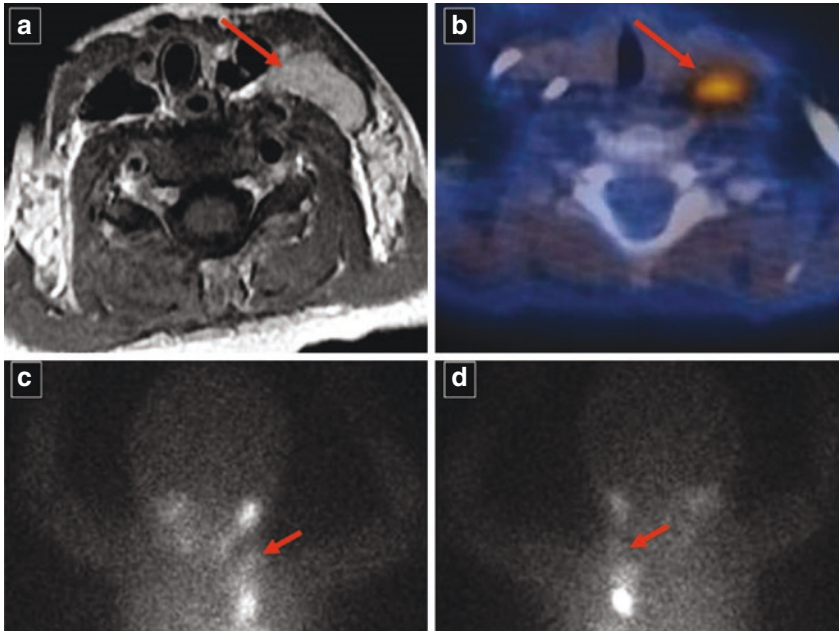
Example of a patient with primary NB diagnosis showing an ancillary nodal involvement in the left supraclavicular region easily visualized with gadolinium-enhanced MRI (a) and ^{18}F -DOPA PET/CT (b); the corresponding lesion seen on ^{123}I -MIBG scintigraphy (c, d) is indicated with the red arrow
